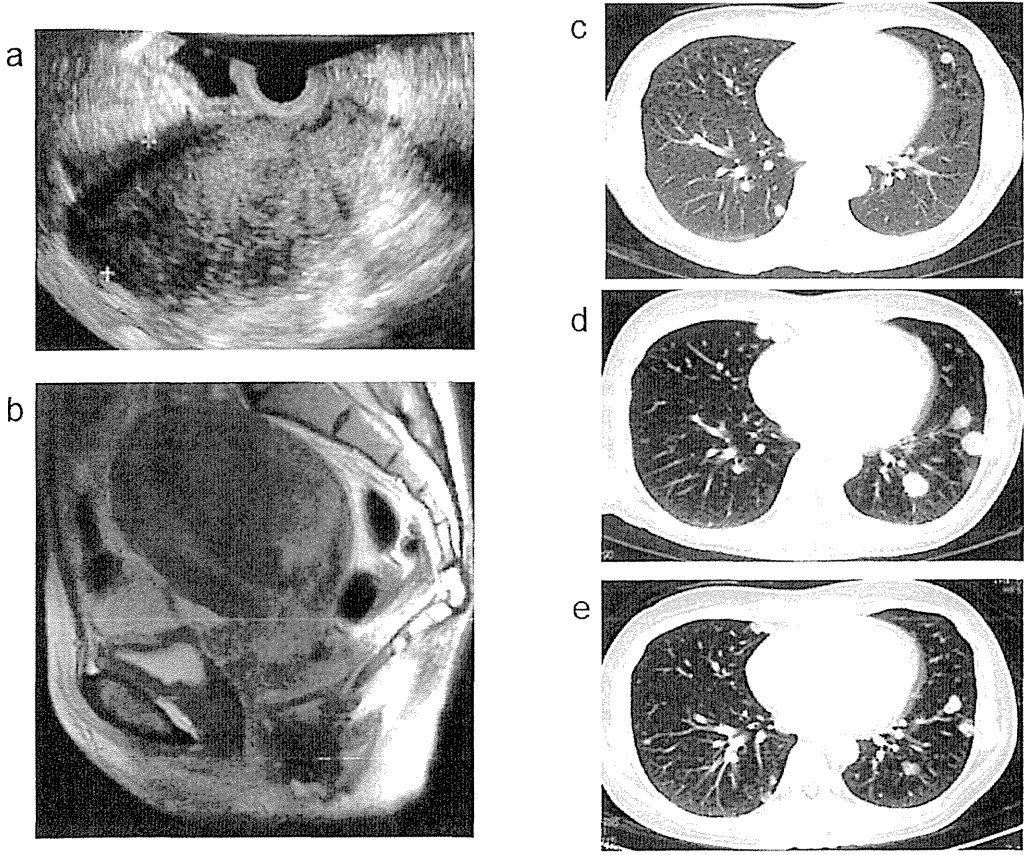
Imaging studies. (a) Transvaginal ultrasound examination of enlarged uterus. (b) Pelvic magnetic resonance imaging (MRI) showing a solid bulky mass measured about 12 cm, filling the uterine cavity and infiltrating the uterine wall. (c) Chest computed tomography (CT) of lung field showing multiple lung metastasis before primary surgery. (d) Lung metastatic regions were enlarged after three cycles of AP treatment. (e) Lung metastatic regions were reduced after three cycles of MEA treatment.
